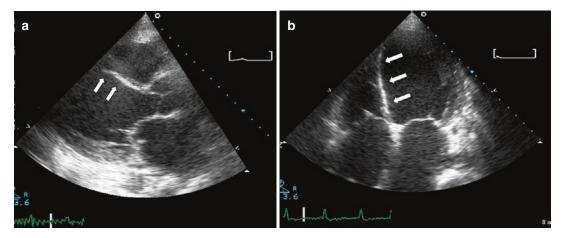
A patient with thinning and scarring of the septum seen in parasternal long axis view (a) and the apical 4 chamber view (b) following LAD infarction
